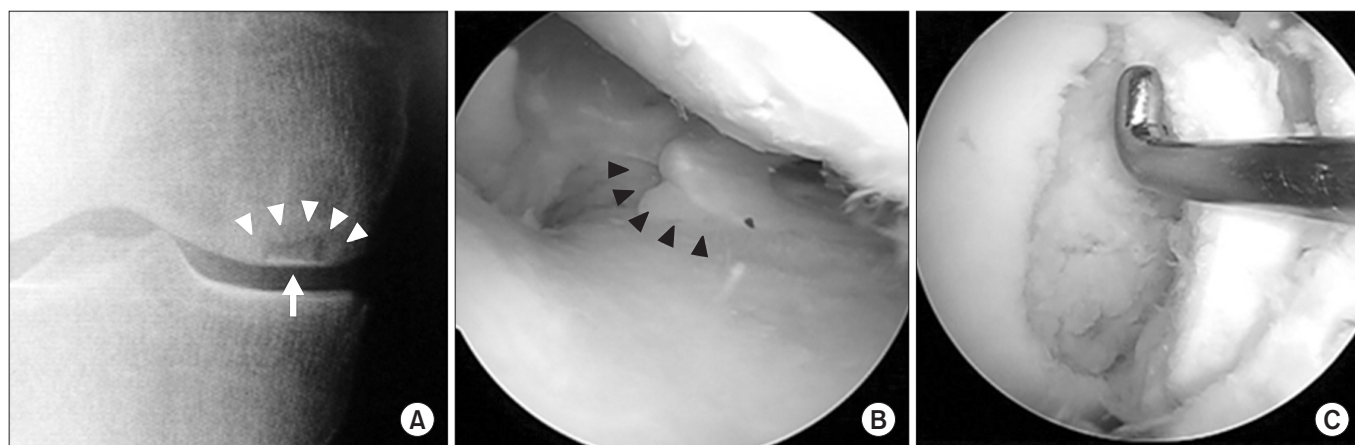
Spontaneous osteonecrosis of the knee following the medial meniscus posterior root tear (MMPRT) in the 65-year-old female shown in Fig. 2 (the right knee). (A) Sclerotic halo (arrowheads) and calcified plate (arrow) were observed in a radiograph at 18 weeks after a painful popping event. Koshino classification: stage 3. (B) Arthroscopic findings at 20 weeks post-MMPRT. Arrowheads: type 2 MMPRT. (C) An unstable osteochondral flap.
